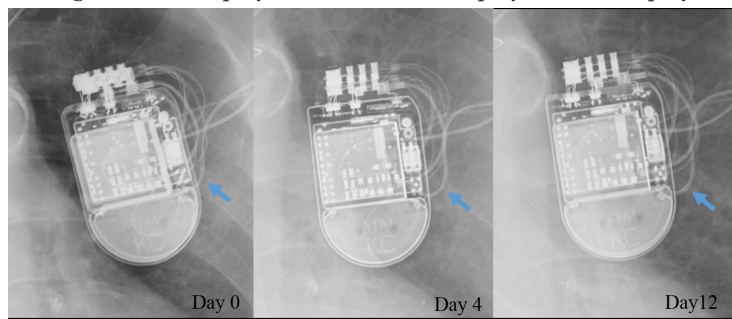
X-ray series showed that a hair-pin curve of the shock lead had been expanding gradually from just after implantation
